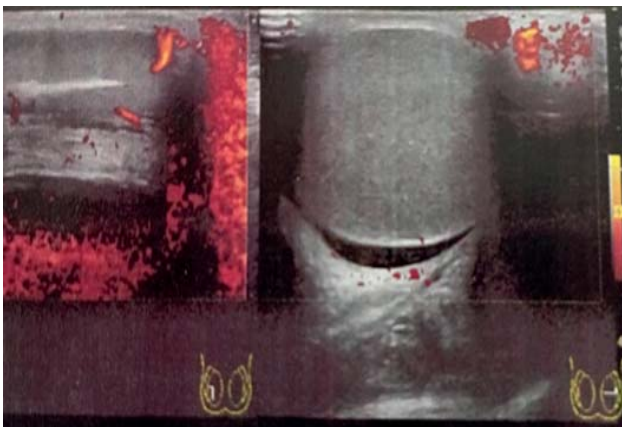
Ultrasound image highlighting Whirlpool sign in ITT (5/6 patients)
